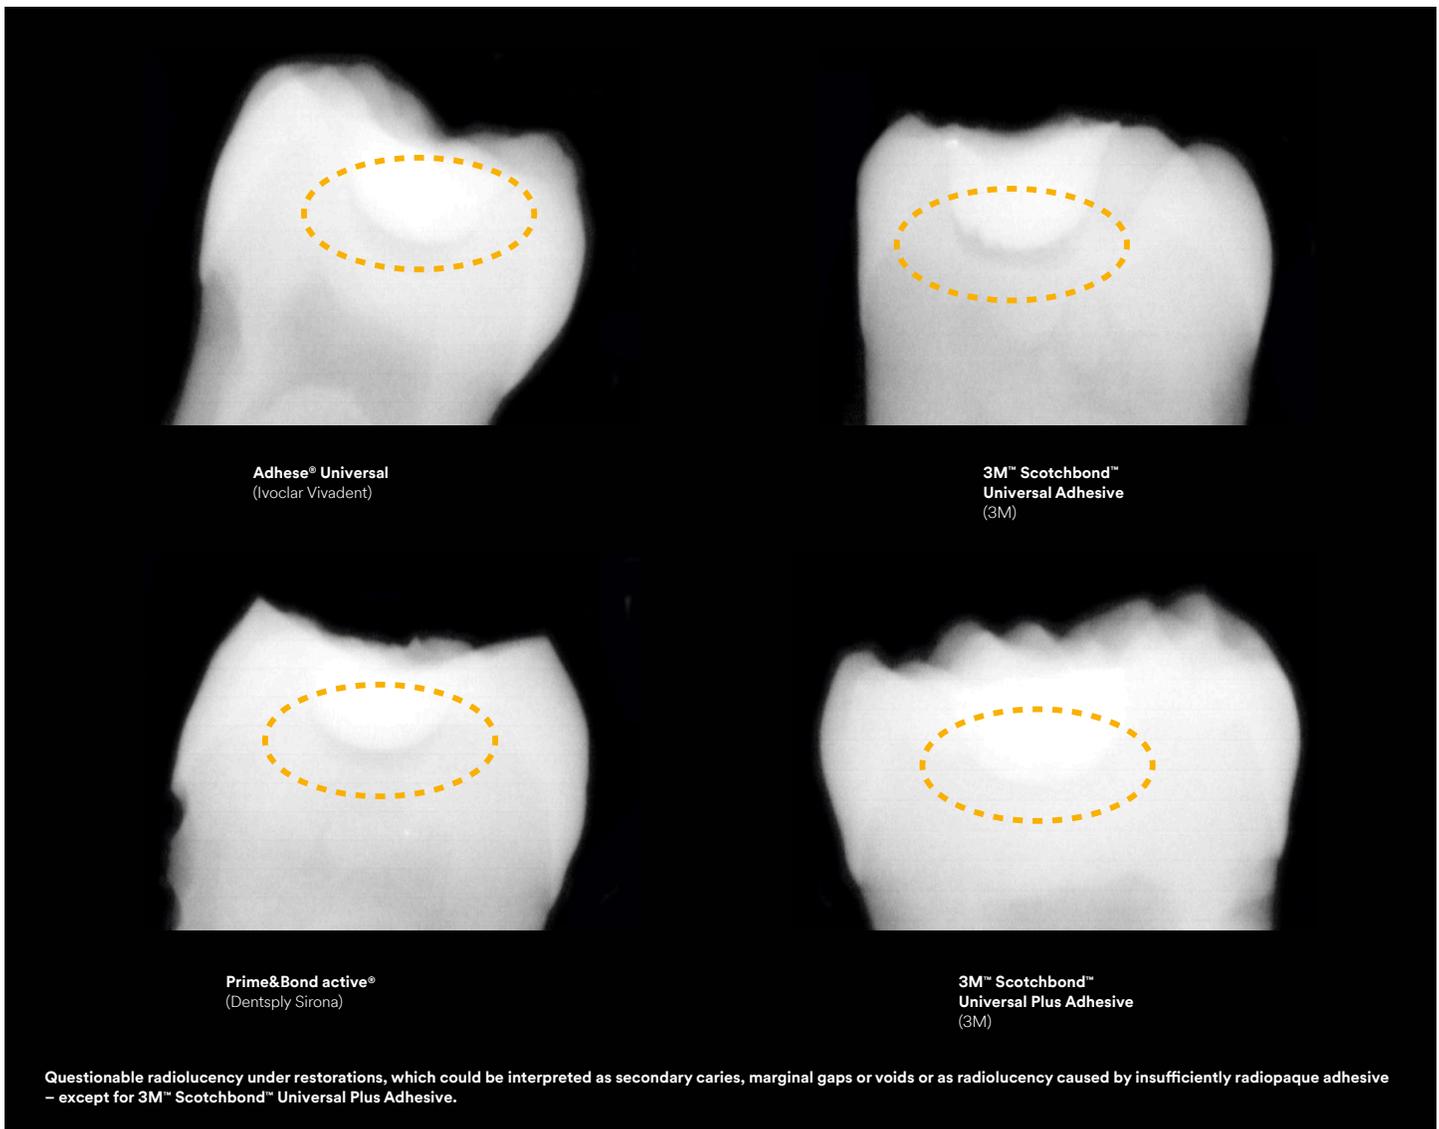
Adhesive pooling – x-rays of Class I restorations in human molars, filling material 3M™ Filtek™ One Bulk Fill Restorative (3M internal data: Radiopacity of an experimental universal adhesive, H. Loll, O. Brinkmann, B. Anich, K. Dede, B. Craig, A.S. Abuelyaman, C. Thalacker, J Dent Res 99 (Spec Iss A): No. 757, 2020)
